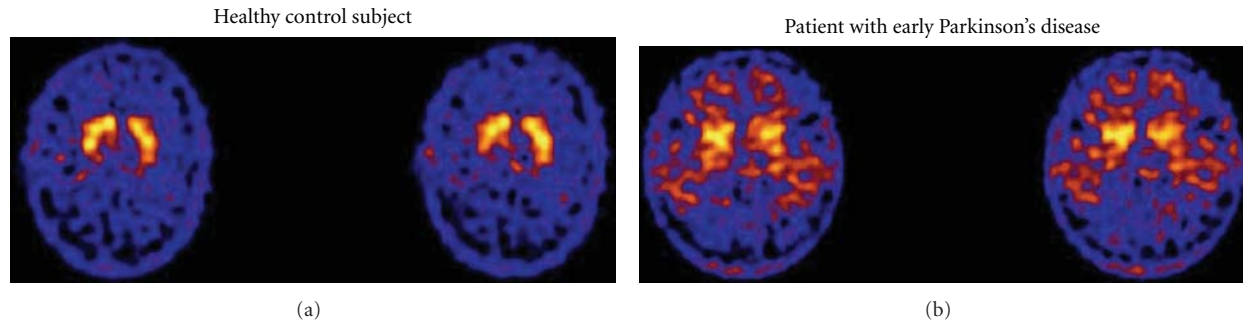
TRODAT-1 SPECT images of a healthy control (a) and a patient with early PD (b). The patient with early PD shows decreased TRODAT-1 uptake in the striatum compared to the control, particularly in the posterior putamen [45].
